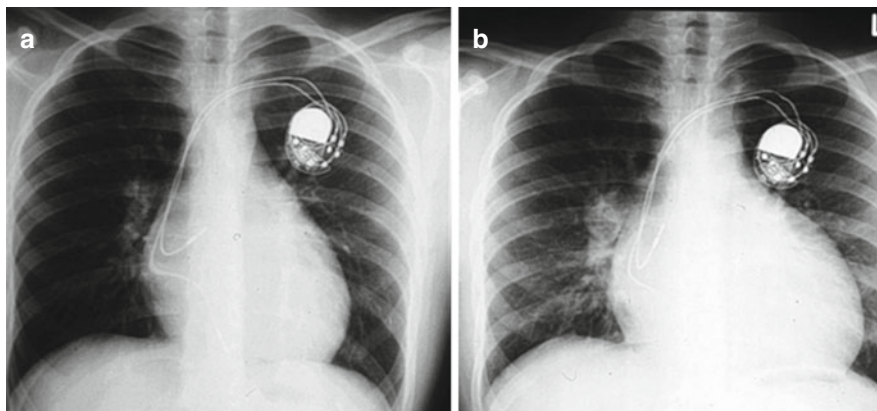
(a, b) Chest x-ray of a 16 year-old-boy with cc-TGA early after implantation of an endocardial pacemaker (a). Implantation of an endocardial pacemaker for heart block may precipitate deterioration in systemic ventricular function and worsen atrioventricular valve regurgitation due to alteration of the ventricular septum, inducing “septal shift” and failure of tricuspid valve coaptation. In this patient, the increased cardiothoracic ratio noted in (b) occurred after the initiation of permanent pacing. In addition, the systemic atrioventricular valve regurgitation increased from mild to moderate and the ejection fraction decreased from 50 to 40 %
